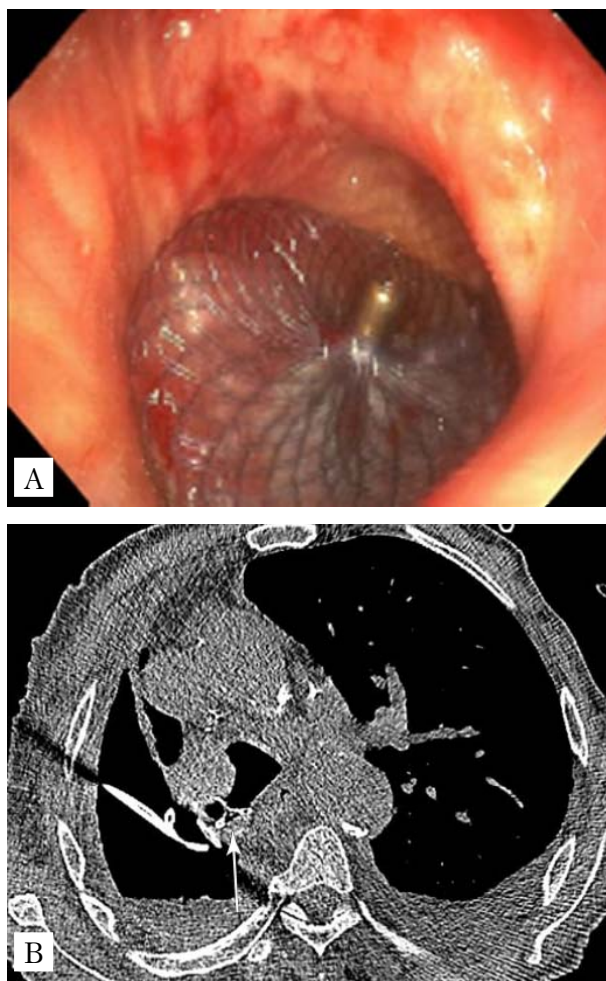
Bronchoscopic view (A) and CT scan (B) demonstrating Amplatzer occluder placement at the bronchopleural fistula of the right upper lobe bronchial stump with chest drainage for seropneumothorax (Case 2)
